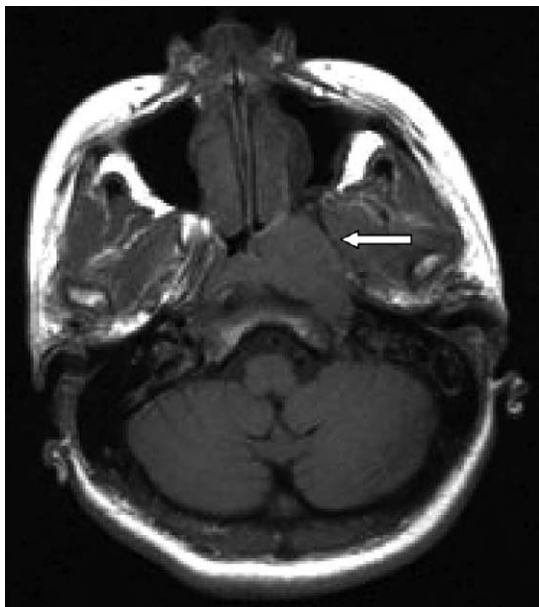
Axial T1-weighted image demonstrates a large iso-intense signal intensity tumor (arrow) measuring $3 \times 2 \times 2$ cm in the left nasopharynx.
